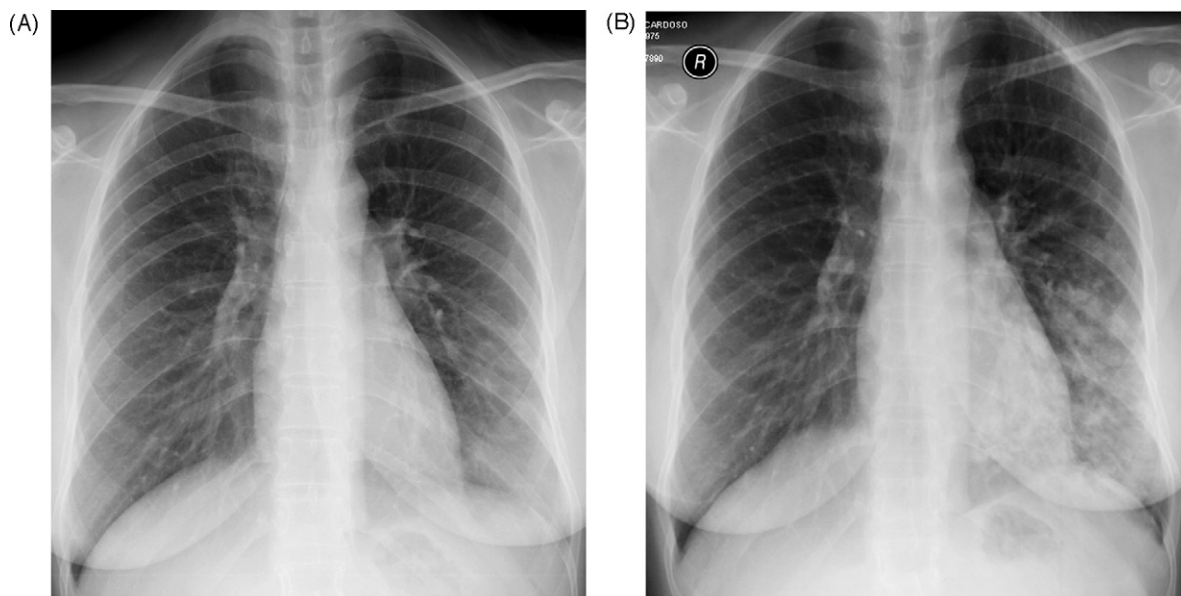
24-year-old female patient with H1N1 pneumonia. (A) Posteroanterior chest radiograph obtained 4 days after the onset of the symptoms shows a mild opacity in the left lower zone. (B) Chest radiography obtained 24 h after (A) reveals patchy areas of consolidation in the left lower region.
